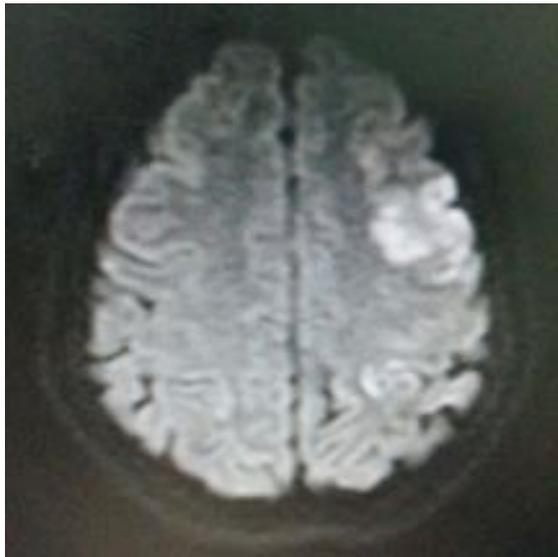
MRI of the patient within three hours
